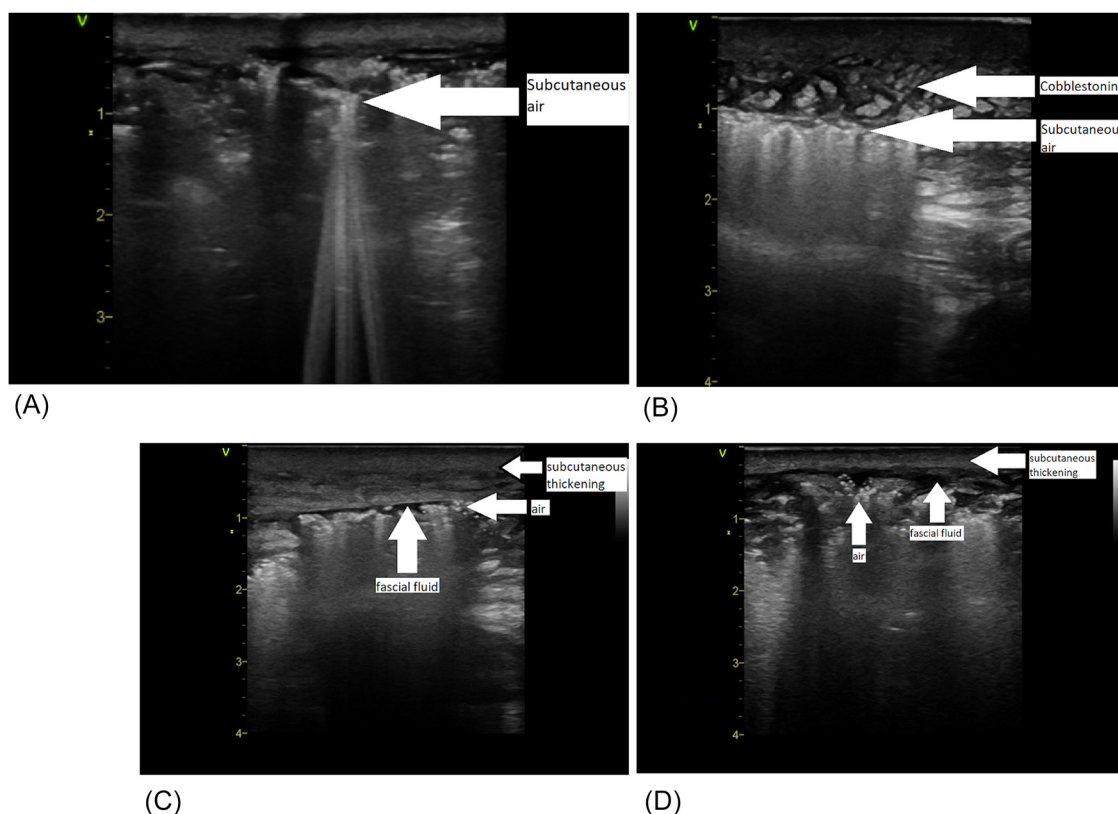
(A) Subcutaneous air noted on bedside ultrasound in a patient with necrotizing soft tissue infection (NSTI). (B) Subcutaneous air noted on bedside ultrasound in a patient with NSTI. Note that there is overlying cobblestoning, a nonspecific finding seen in soft tissue edema. Were it not for the subcutaneous air, this could easily have been misdiagnosed as cellulitis based on the image alone. (C) Subcutaneous thickening, air, and free fluid in the fascial plane. (D) Subcutaneous thickening, air, and free fluid in the fascial plane. Courtesy of Dr. Jonathan Nogueira, DO.
